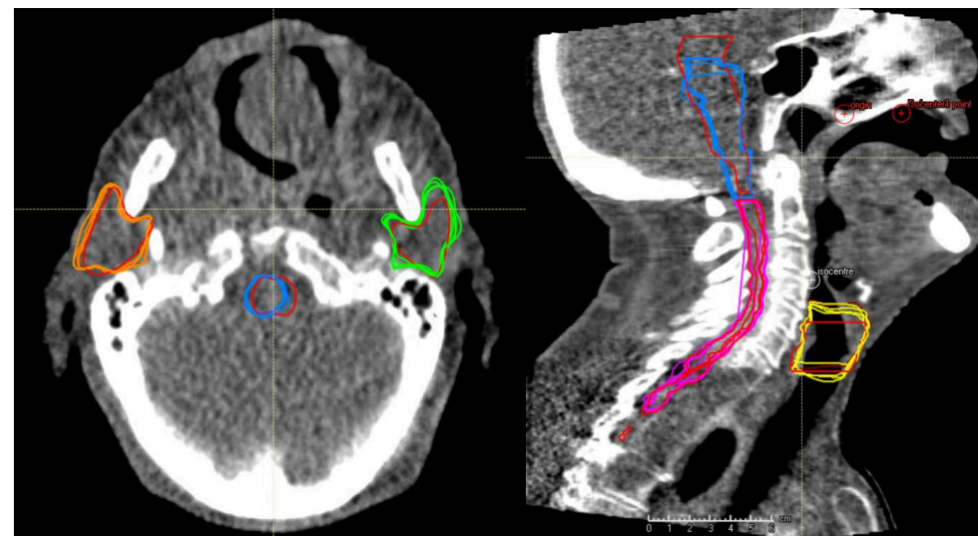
Example of a single CBCT showing all propagated contours and the clinician contours (red).
